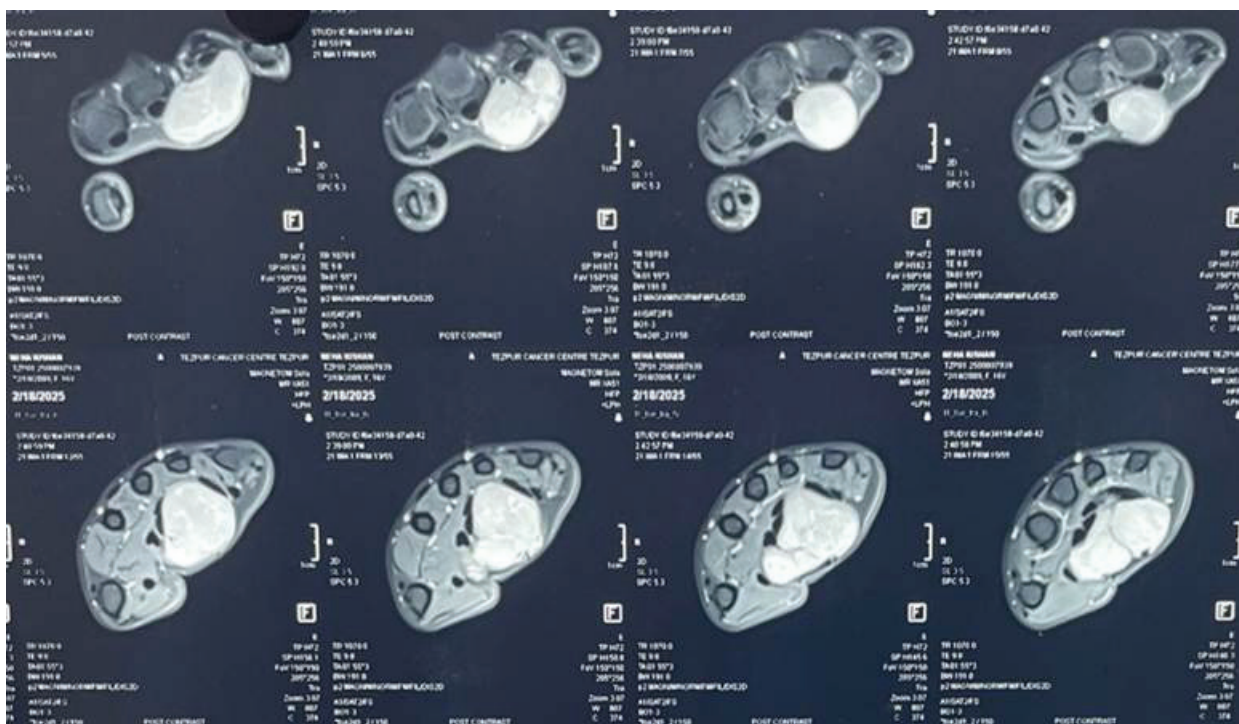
MRI of the wrist and hand showing distal extension of the lesion along the median nerve into the palmar aspect of the hand.
